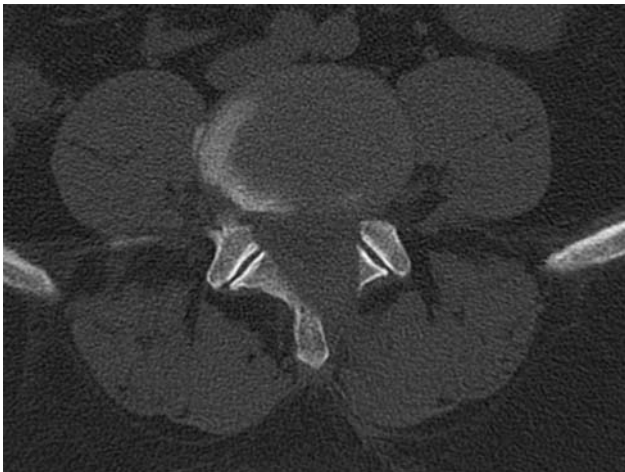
Postoperative CT-scan after full-endoscopic bilateral decompression.
